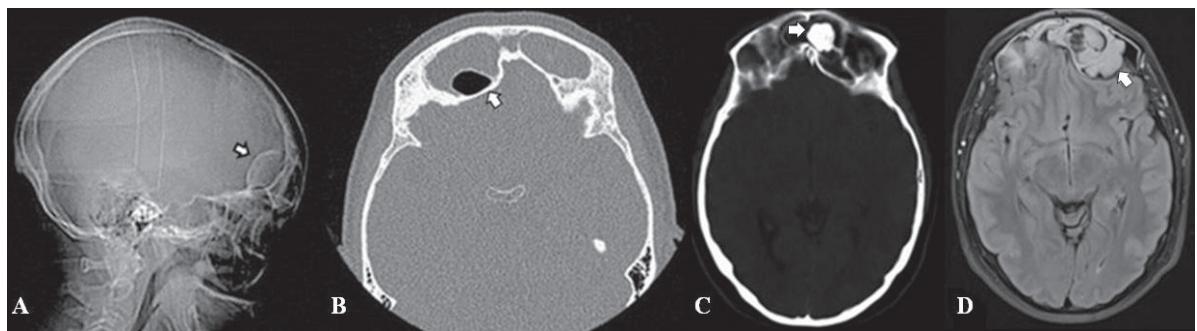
(A) and (B): Frontal mucocele in a patient suffering from headache for 3 years - deformation and bulging of the posterior wall of the frontal sinus detected on plain x-ray and CT scan (white arrows); frontal mucocele in a patient suffering from headache for 4 years - (C) presence of osteoma obstructing the opening of the frontal sinus; (D) T2 FLAIR MRI: high signal intensity suggestive of long duration of the frontal mucocele.
